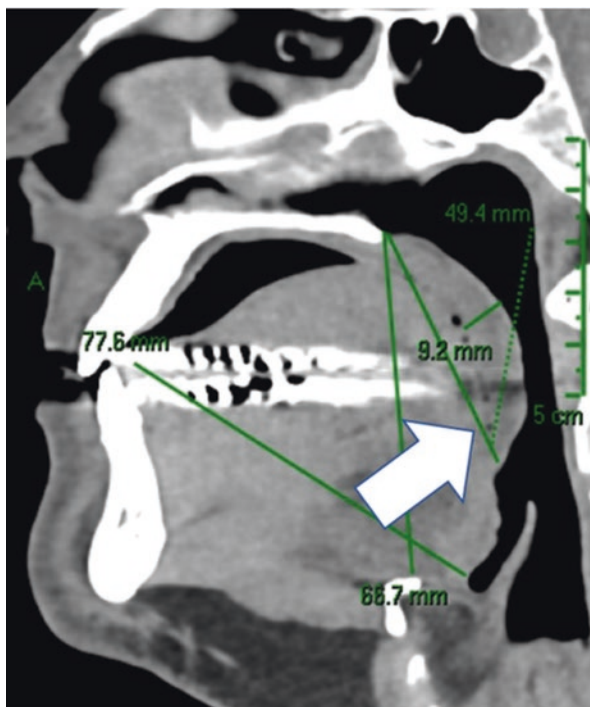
Computed tomography of sinuses showing elongated soft palate (white arrow). (Image courtesy from Dr. Vivien Schmeling Piccin (original figure))
